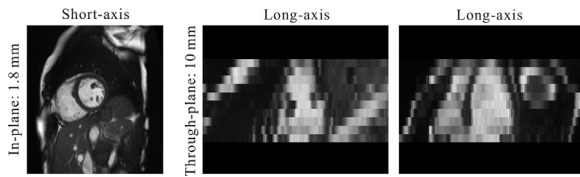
An example of typical cardiac MR images from the UK Biobank with in-plane spatial resolution 1.8×1.8 mm, through-plane resolution 10 mm. From left to right, the three images display a short-axis (SAX) slice, two long-axis (LAX) slices, respectively. While in-plane spatial resolution is sufficient for image analysis, slice spacing is large due to acquisition constraints and hardly captures the detailed anatomy.
